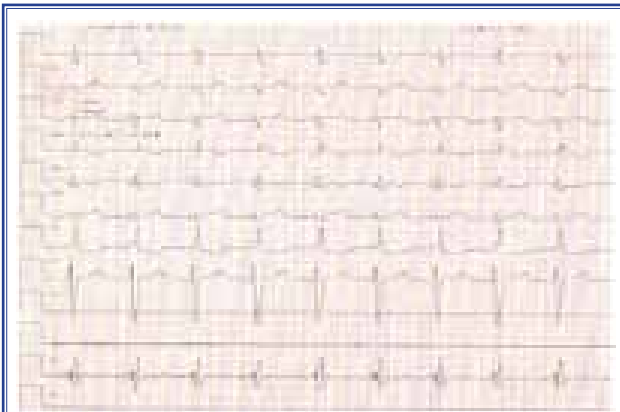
Transesophageal electrophysiologic study showed absence of atrial electrical activity in basal state.
